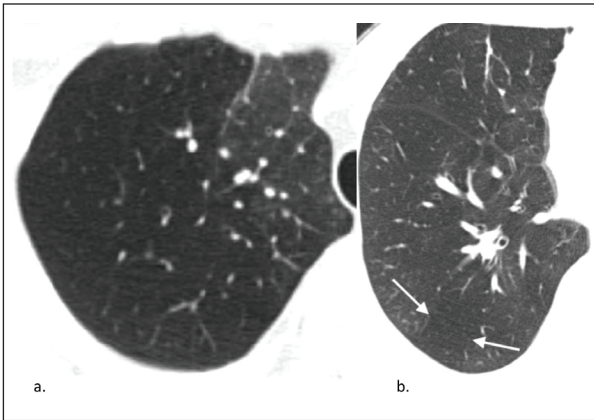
36-year-old PR3 positive AAV male (a) and 60-year-old MPO positive female (b), both non-smokers. Select axial HRCT images in lung window reveal low attenuation areas categorized as “obstructive” involving the majority of the right upper lobe in 36-year-old male. More regional areas of obstruction (arrows) are present in the 60-year-old female.
